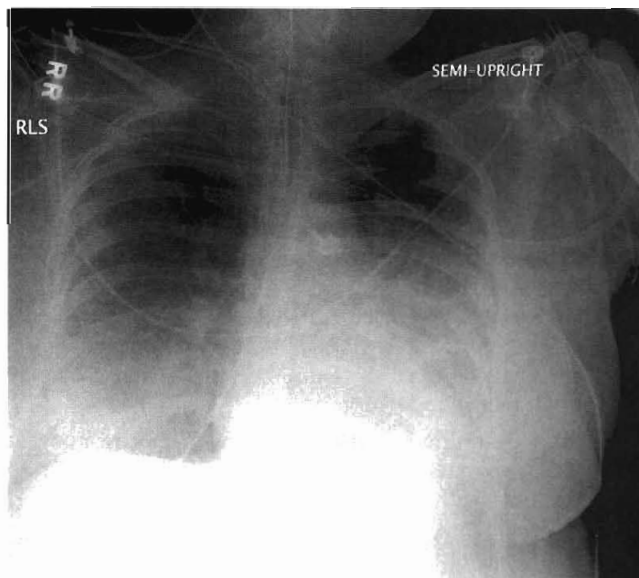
A semi-upright anteroposterior chest radiograph shows bilateral alveolar infiltrates and pleural fluid veiling consistent with pleural effusions.
